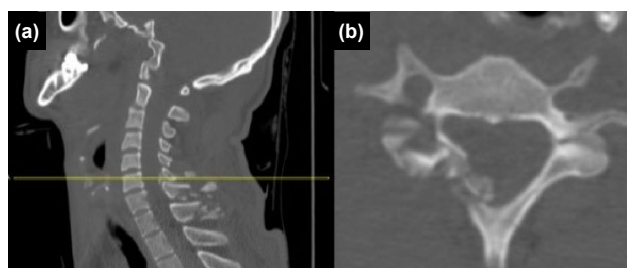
(a, b) Computed tomography (CT) scan of the cervical spine showing a pedicle and lamina fracture of the C6 vertebra, along with multilevel fractures of the spinous processes.
